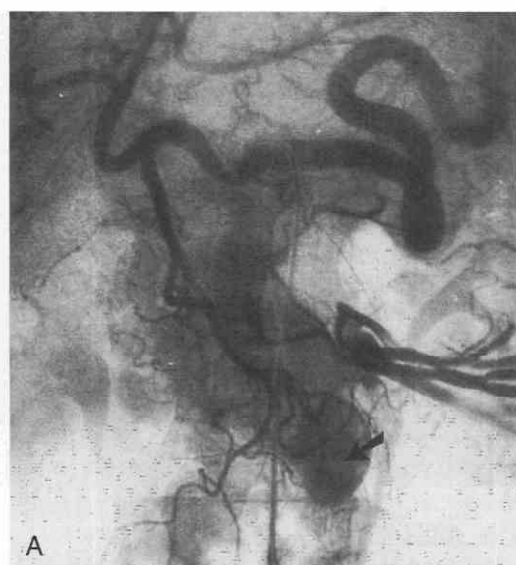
Elevated gastrin levels in a 65-year-old man. *A*, Celiac arteriogram. A vascular mass (*arrow*) is near the origin of the superior mesenteric artery. *B*, Noncontrast CT scan. A gastrinoma (*arrow*) is indistinguishable from nonopacified bowel. *C*, Dynamic CT scan with intravenous bolus of contrast material shows a brightly enhancing gastrinoma (*arrow*) behind the third part of the duodenum. At surgery, an extrapancreatic gastrinoma was found in the lymph node near Treitz's ligament.
